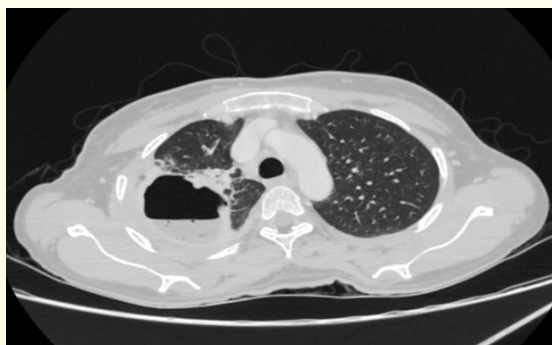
CT Chest Images – Dated 11-03-2024.
